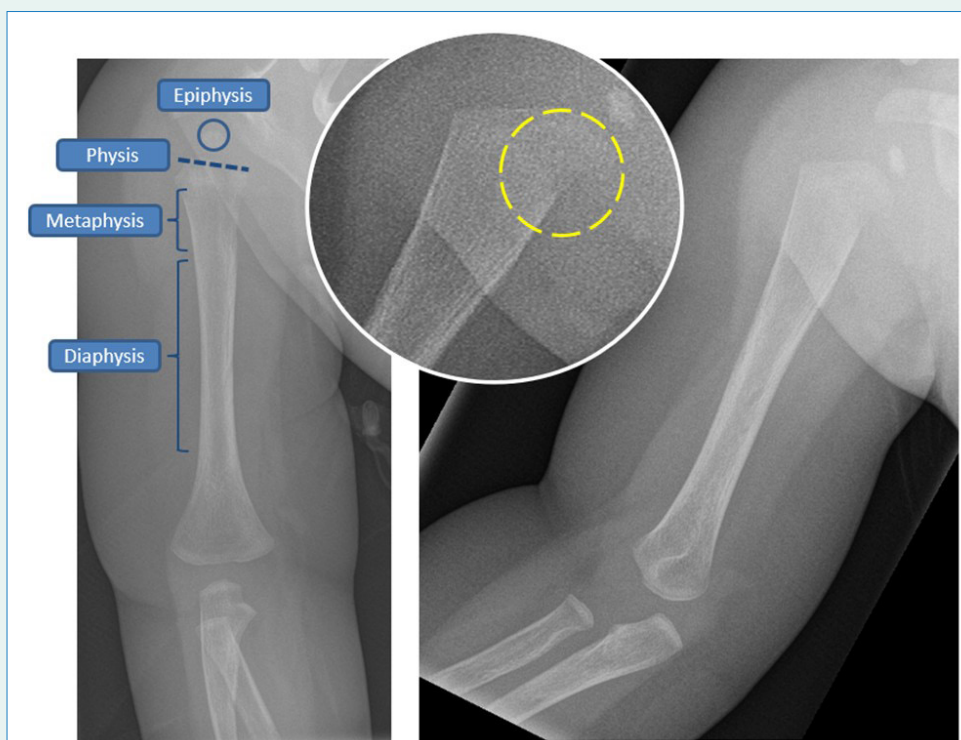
Annotated anterior-posterior and lateral radiographs of the right humerus and shoulder. The enhanced image of the shoulder shows lucency in the proximal humerus (yellow circle).
